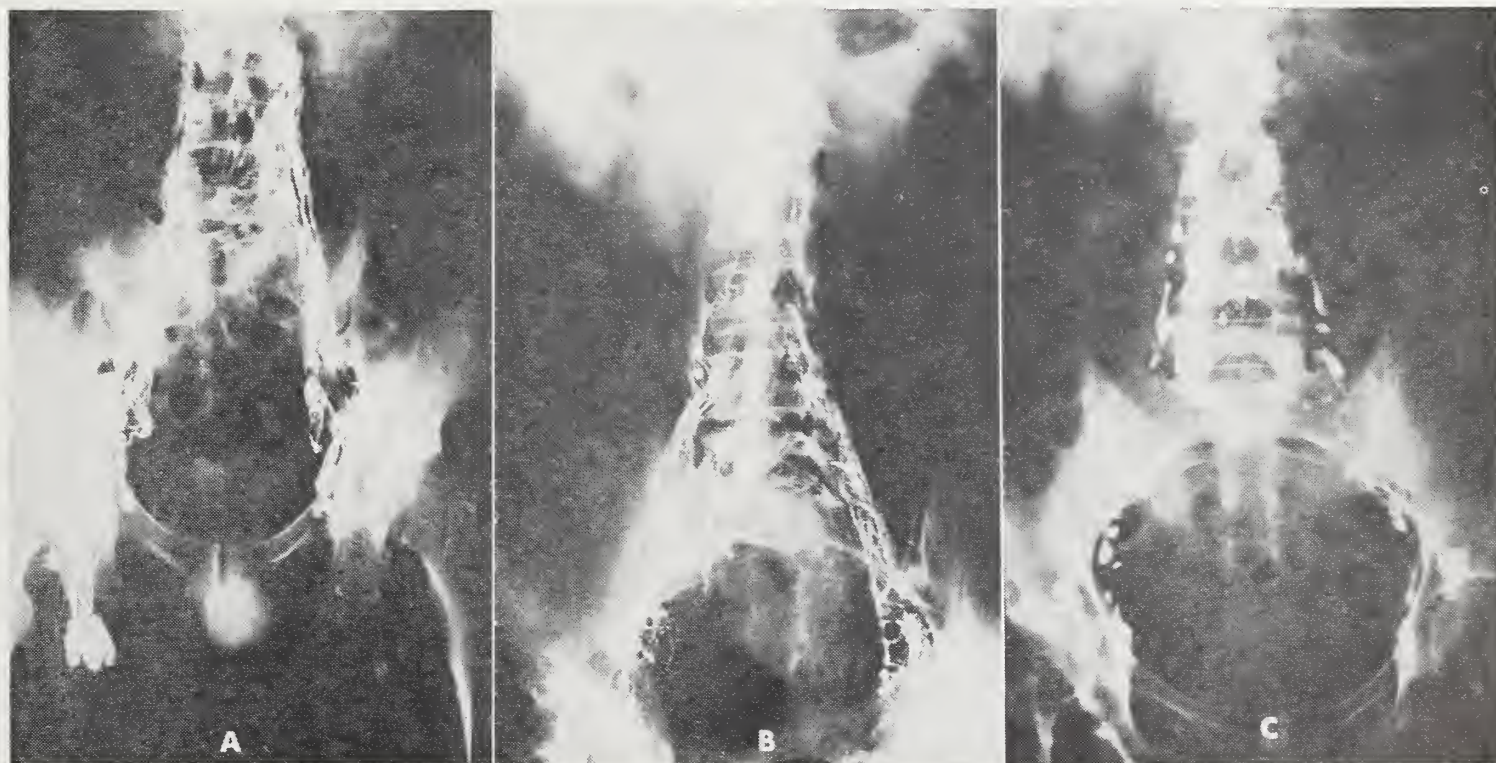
Normal lymphatic distribution. A) pelvic, inguinal, external and common iliac areas; B) para-aortic lymphatics and nodes; C) para-aortic nodes (24 hour roentgenogram).
